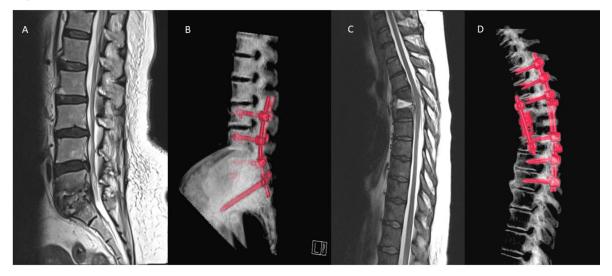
A) Preop MRI image of vertebral defect due to spondylodiscitis in the lumbar region B) Postoperative CT image C) Preop MRI image of vertebral defect due to spondylodiscitis in the thoracic region D) Postoperative CT image MRI: Magnetic resonance imaging, CT: Computed tomography
